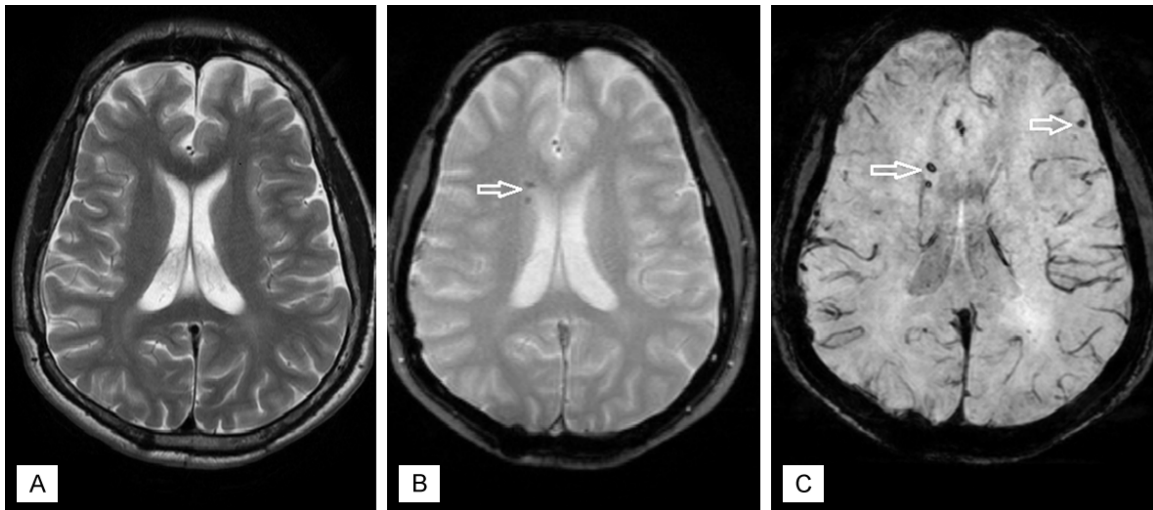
A. Axial T2-weighted image shows no significant abnormalities. B. Axial T2*-weighted GRE image shows a small two foci of low signal intensity (arrow) on the right subependymal region. C. SWI demonstrates the subependymal lesions (arrow), in addition, shows a left frontal lesion (arrow), which was not seen on T2*-weighted GRE image.
